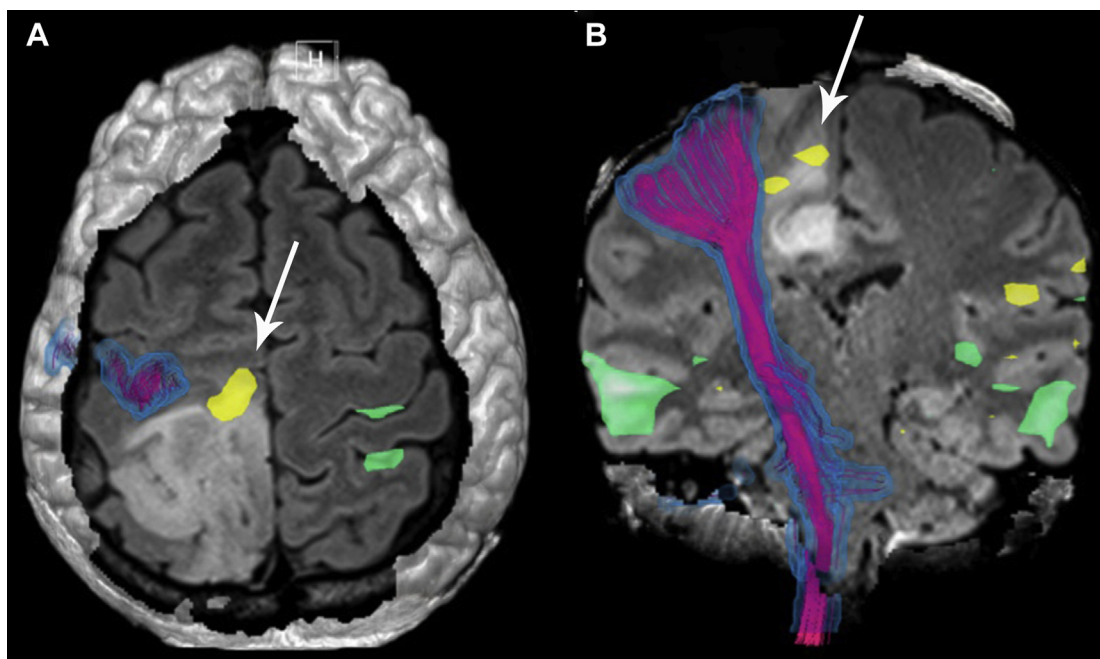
(A) Axial and (B) coronal 3D-FLAIR images of a right parietal IDH-mutated glioma. The CST (pink) medial fibers to the leg/foot area of the right precentral gyrus are not visualized because of decreased FA from tumor infiltration. Foot motion was intact during patient training and superimposed functional MR imaging ankle flexion task data (yellow) show activity (arrows). Reporting the medial CST fibers are functioning even though not recognized by the tractography algorithm is crucial for surgical planning.
